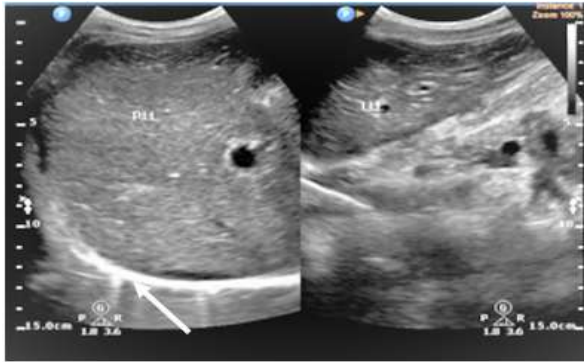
The patient's first ultrasound results with indications of Acites Pleural Dextra.
